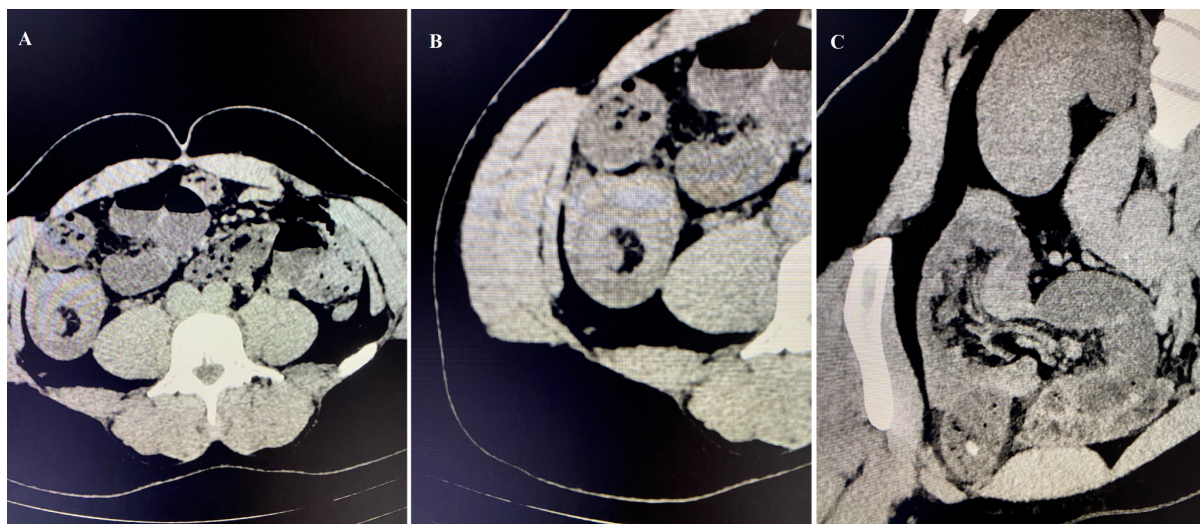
Computed tomography cross-section images showing ileocecal intussusception. A. Axial image section characteristic of intussusception (target sign). B. Detail (target sign). C. Coronal-oblique reconstruction image, showing the mesentery within the ascending colon.
